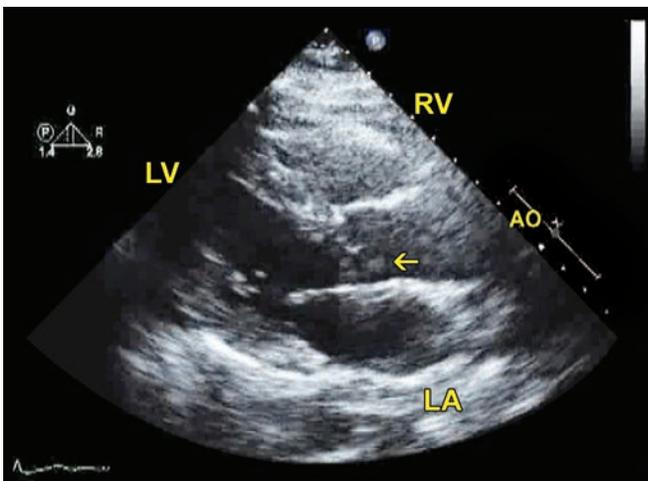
Transthoracic parasternal long axis view. Arrow points to a mass attached to aortic valve leaflet.
